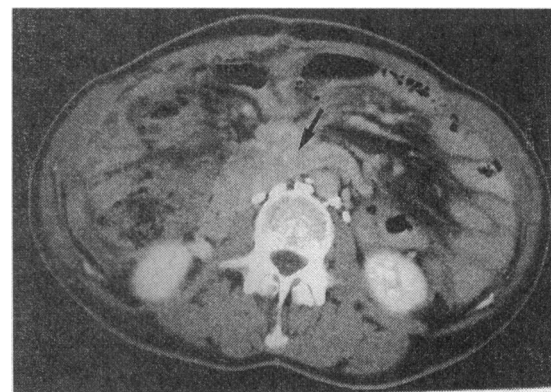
Enhanced abdominal computed tomogram showing tumour mass arising from root of small bowel mesentery (arrow)
